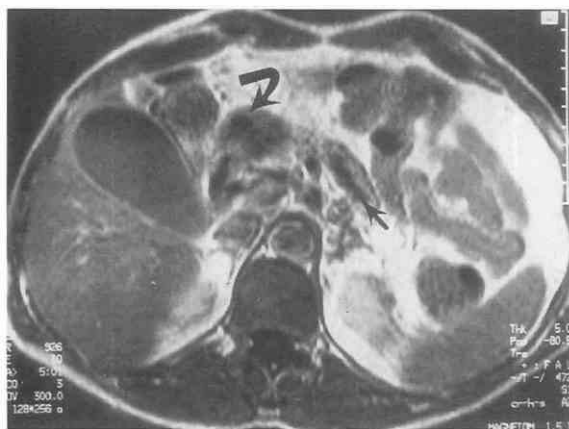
MR image (SE 926/10) shows pancreatic cancer (curved arrow) in the head of the pancreas, producing distal ductal dilatation (arrow).
